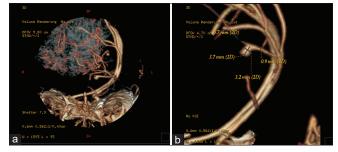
Anterior-coronal 3D CT angiogram: (a) vascularization of giant convexity meningioma; (b) A2 pseudoaneurysm (3.7 mm).
